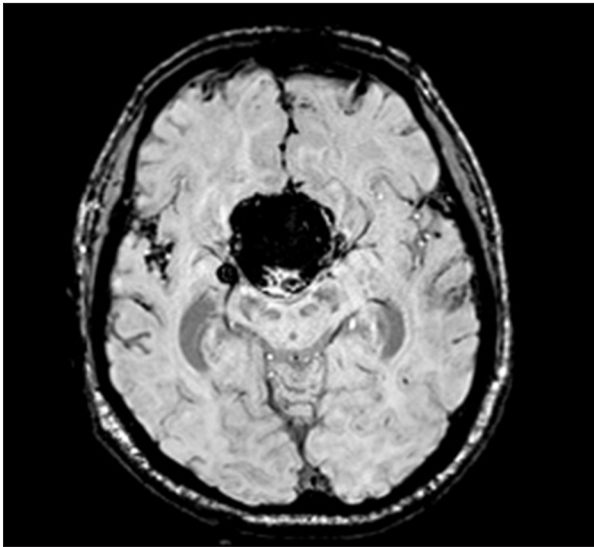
MRI axial SWI showing dark blooming within the mass, indicating underlying hemorrhage.
